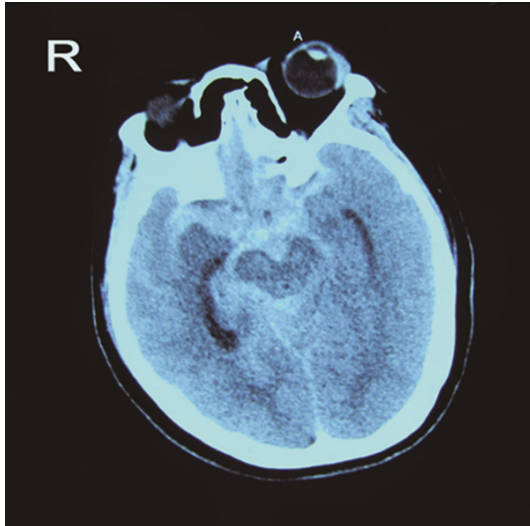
Computed tomography of the head showing diffuse subarachnoid hemorrhage especially concentrated in ambient, interpeduncular and suprasellar cisterns.
